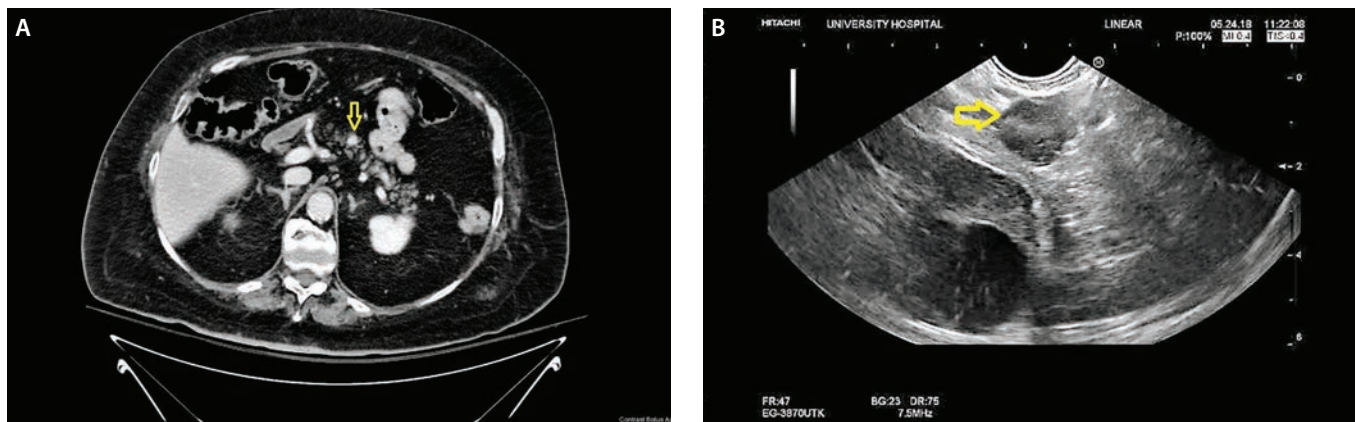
Pancreatic neuroendocrine tumor (NET). Computed tomography scan (a) and endoscopic ultrasound (b) show a small smoothly circumscribed tumor with fairly homogeneous texture in the body of the pancreas.
